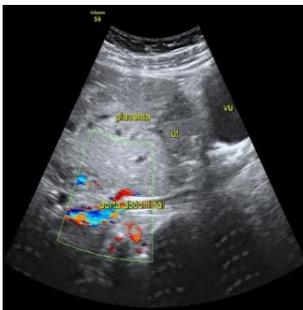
Ultrasound showed a placental-like mass with irregular walls attached to the abdominal aorta
